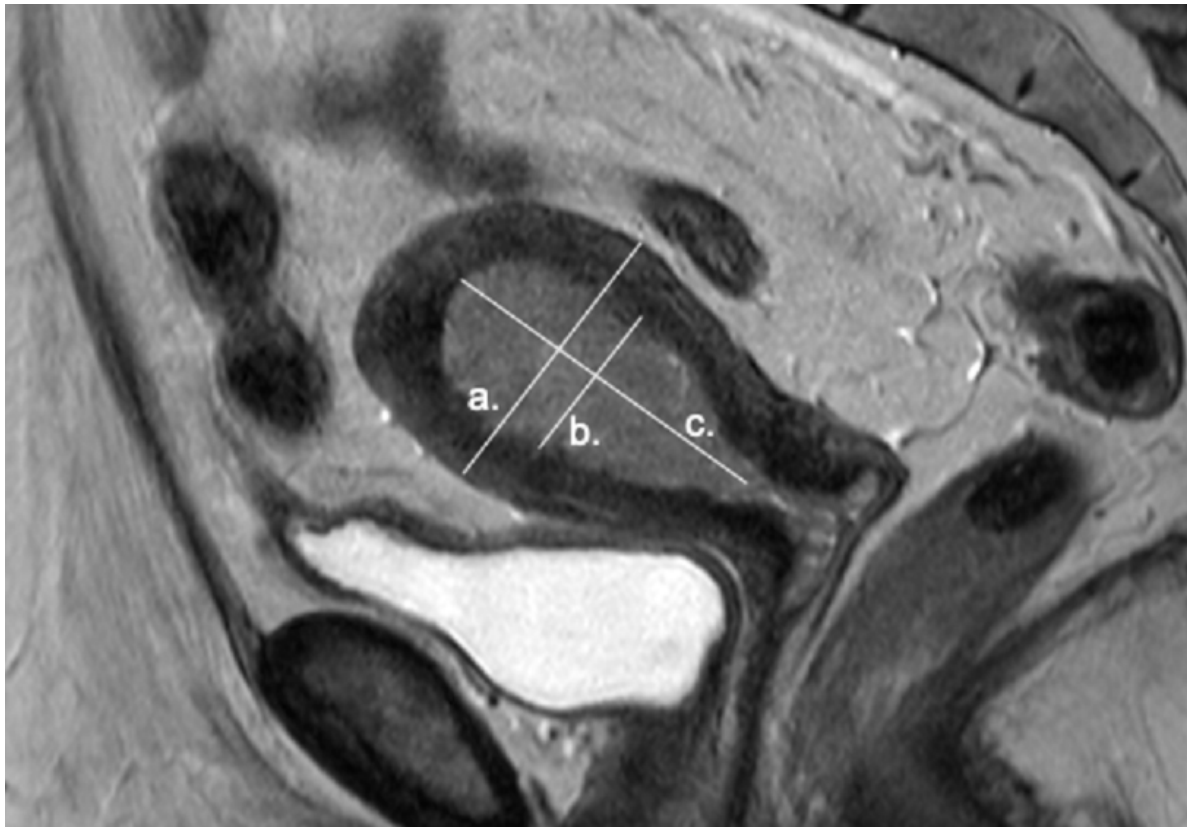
Example of MRI in the PODEC study, T2-weighted sequence. Patient with FIGO grade 2 endometrioid endometrial cancer, assessed as deep myometrial infiltration. Lines a, b and c corresponding to the measurements in the case report form (CRF).
